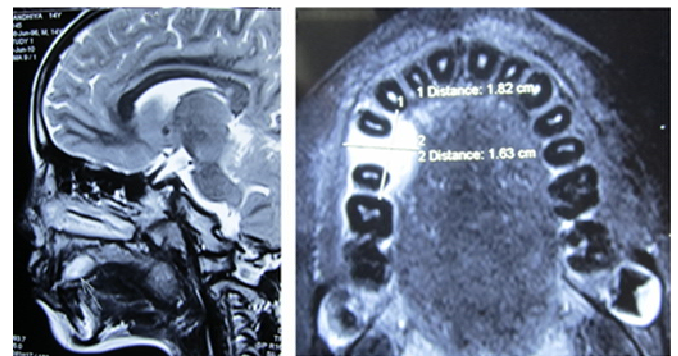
MRI--- T2W Axial and Sagittal
